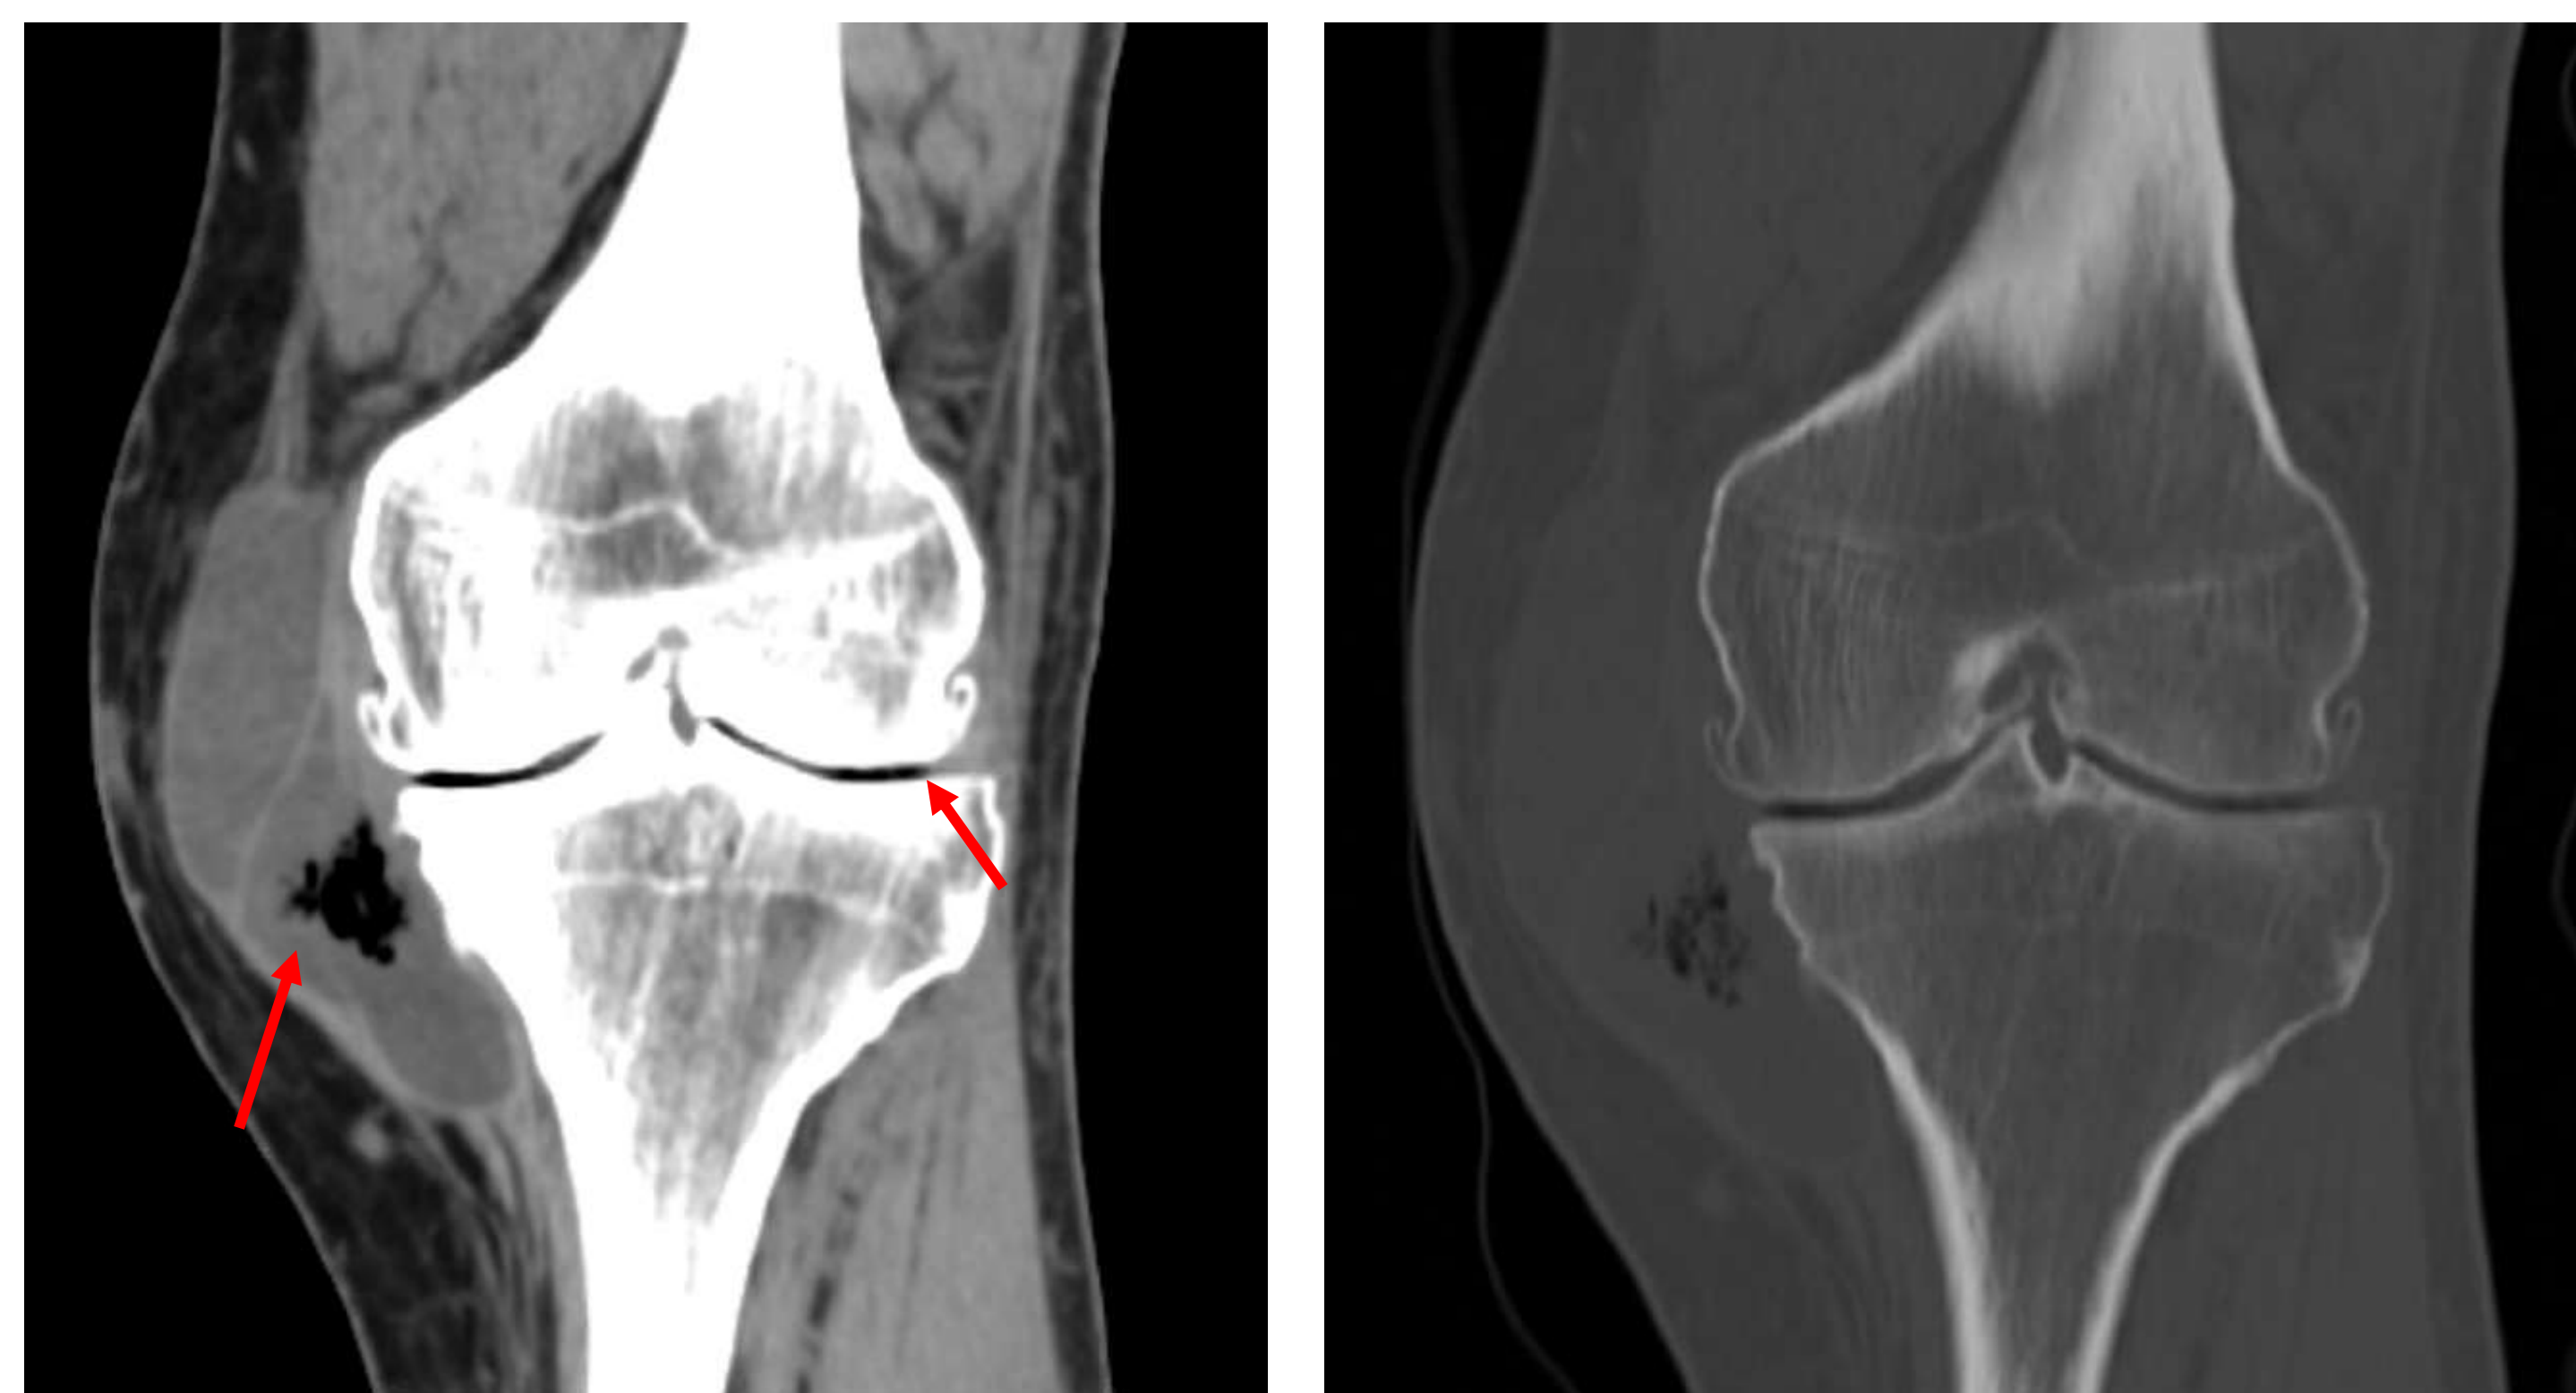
Coronal CT of the left knee with soft tissue windowing (left) and bone windowing (right) obtained at the time of the radiograph, demonstrating a gas and fluid filled septated parameniscal cyst. Note the gas in the knee joint spaces. No gas is seen linearly tracking through any other soft tissues, as what is typically seen in necrotizing fasciitis.
